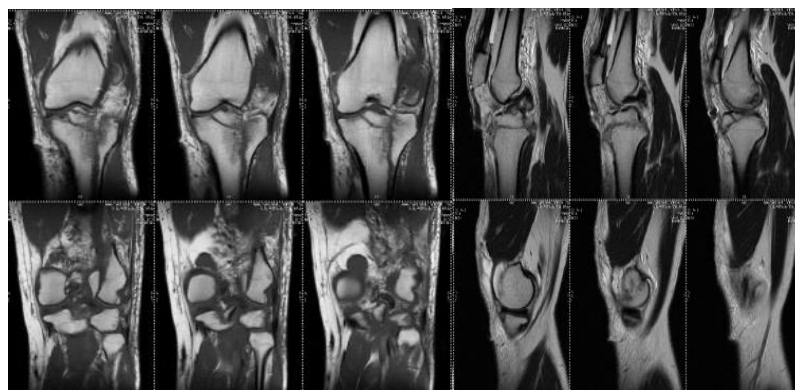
Preoperative MRI coronal and saggital view showing displaced intra-articular fracture of lateral femoral condyle and lateral tibial plateau with displaced fracture of patella with Grade II ACL tear and PCL sprain and complex tear of lateral meniscus and extensor mechanism rupture
